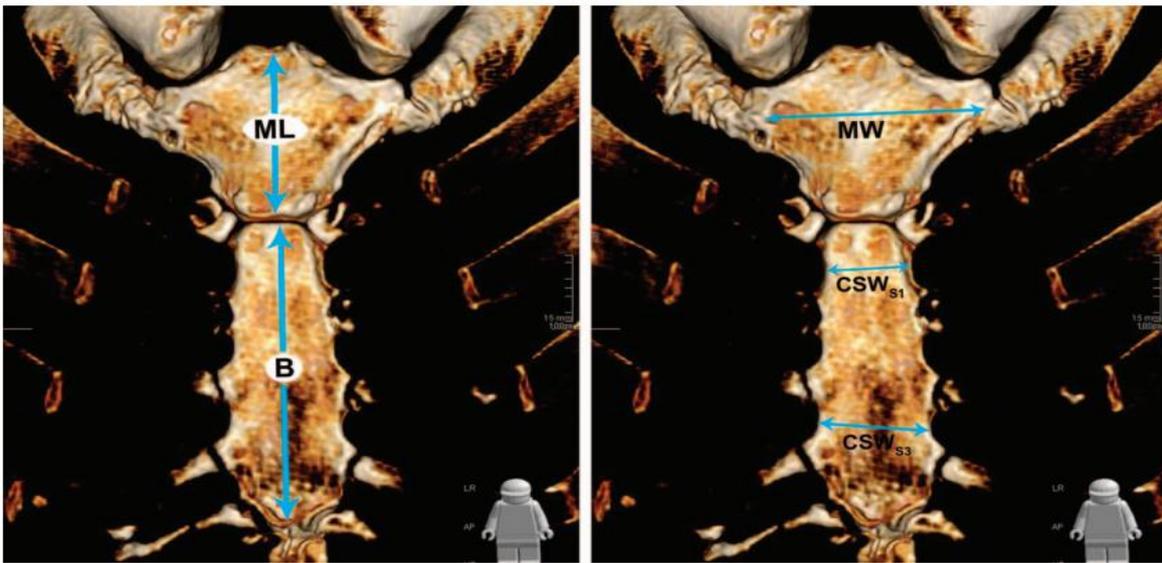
Reconstructed three – dimensional computed tomography of sternum showing the measurements used in the present study. (ML) manubrium length; (MW) manubrium width. (B) sternal body length; (Csw1) width of sternum at 1st sternal depression; (Csw3) width of sternum at 3rd sternal depression.
